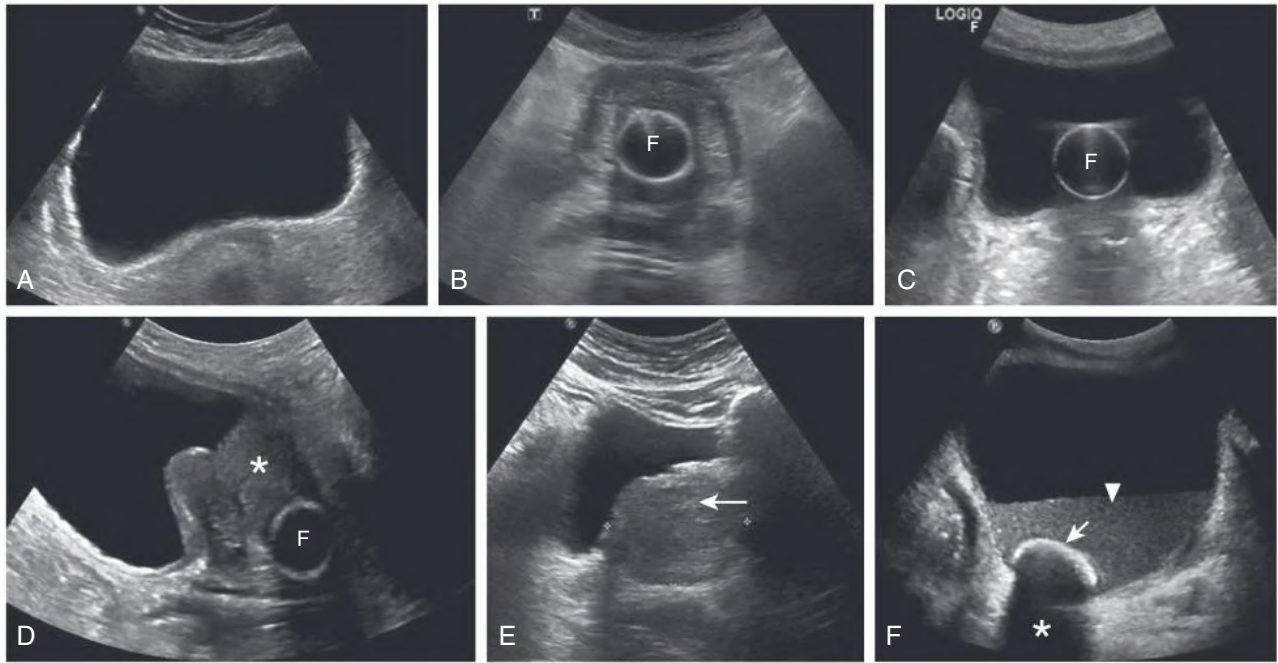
(A) Normal urinary bladder ultrasound, transverse plane. (B) Decompressed bladder with Foley catheter. (C) Bladder filled with anechoic urine despite having a Foley catheter indicative of obstructed catheter. (D) Misplaced Foley catheter balloon in prostatic urethra; *asterisk* indicates prostate gland. (E) Enlarged prostate gland (*arrow*) compressing the bladder. (F) Bladder stone (*arrow*). Note the acoustic shadowing (*asterisk*) and surrounding debris (*arrowhead*). F, Fluid-filled balloon of the catheter.
